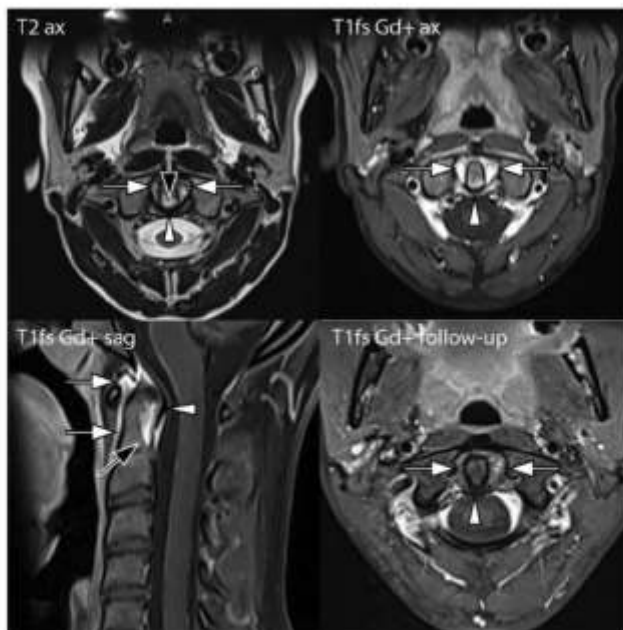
A series of MR images of the cervical spine of 14-year-old and 16-year-old girls with extended oligoarticular JIA, antinuclear antibodies-positive baseline images in T2 axial, T1 fs contrast-enhanced axial and sagittal, and follow-up T1 fs postcontrast image in axial plane (last bottom image). Baseline T2 turbo spin-echo axial shows asymmetrically thickened atlanto-axial synovium (arrows), area of hyperintense bone marrow signal in the posterior part of the dens (black arrow), and thickened transversal ligament (arrowhead). Contrast-enhanced MR image in axial and sagittal planes shows homogenous intensive synovial enhancement, enhancement of the posterior part of the dens and thickened transverse ligament, and no signs of anterior atlantoaxial subluxation. The contrast-enhanced MR image on follow-up obtained 2 years later, during which time the girl was treated with biologics, shows slightly asymmetric thickened synovium with minimal non-homogenous enhancement
